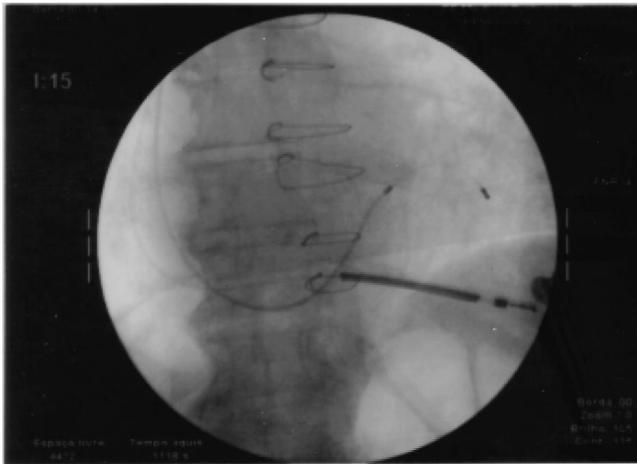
Posterior-anterior radiography of a patient with an ICD, implanted due to dilated cardiomyopathy, atrial fibrillation, low ventricular response, and malignant ventricular arrhythmia. Observe the ICD lead positioned on the infero-apical right ventricular wall, and the coronary sinus lead positioned on the side wall of the left ventricle.
